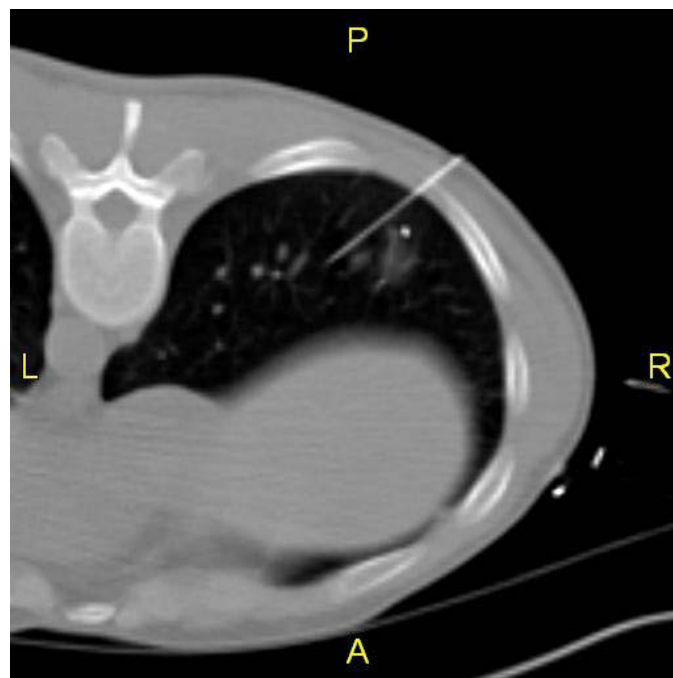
Image from a CT fluoroscopy procedure showing needle insertion into the lung. The clinician is inserting tiny gold fiducials into a tumor for stereotactic radiosurgery guidance.
